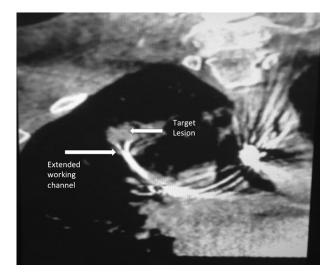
Cone beam computed tomography imaging demonstrates the extended working channel in the target lesion.
